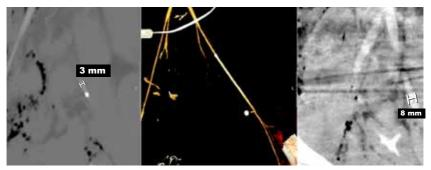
5Fr sheath in a trauma patient (left to right). Thrombus and ischemia after REBOA later on with 11Fr sheath. The patient was hypovolemic and you can see the size differences: Left and middle photos first CT during hypovolemic shock, on the right side, the vessels at their normal size, on CTA after rescucitaion.
